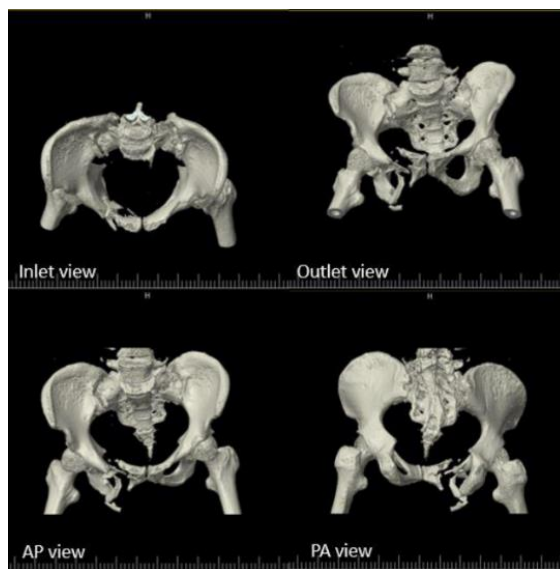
Pre-operation 3D CT-scan
